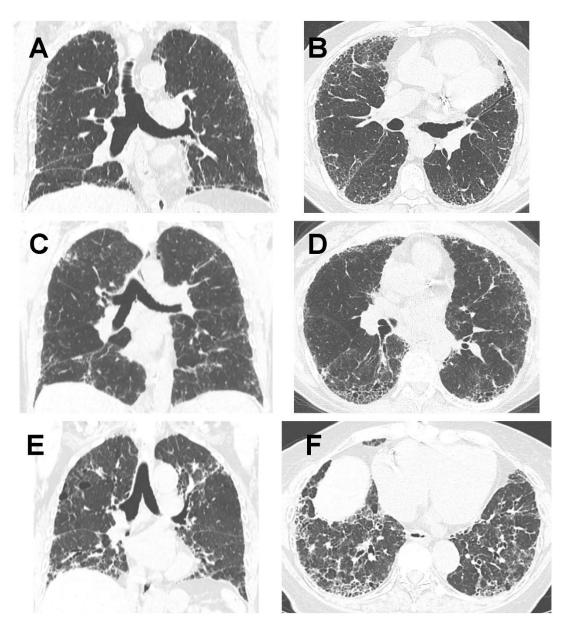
Representative high-resolution computed tomography (HRCT) chest images from adult pulmonary fibrosis patients with rare, deleterious variants in telomere related genes. A 78 year old man heterozygous for *TERT* p.Cys76Stop (A, B), a 55 year old man heterozygous for *PARN* c.1222+1G>T (C, D), and an 81 year old female heterozygous for *RTEL1* p.lle110frameshift (E, F). Coronal images at the level of the carina are shown in A, C, and E. Axial images are shown in B, D. and F.
